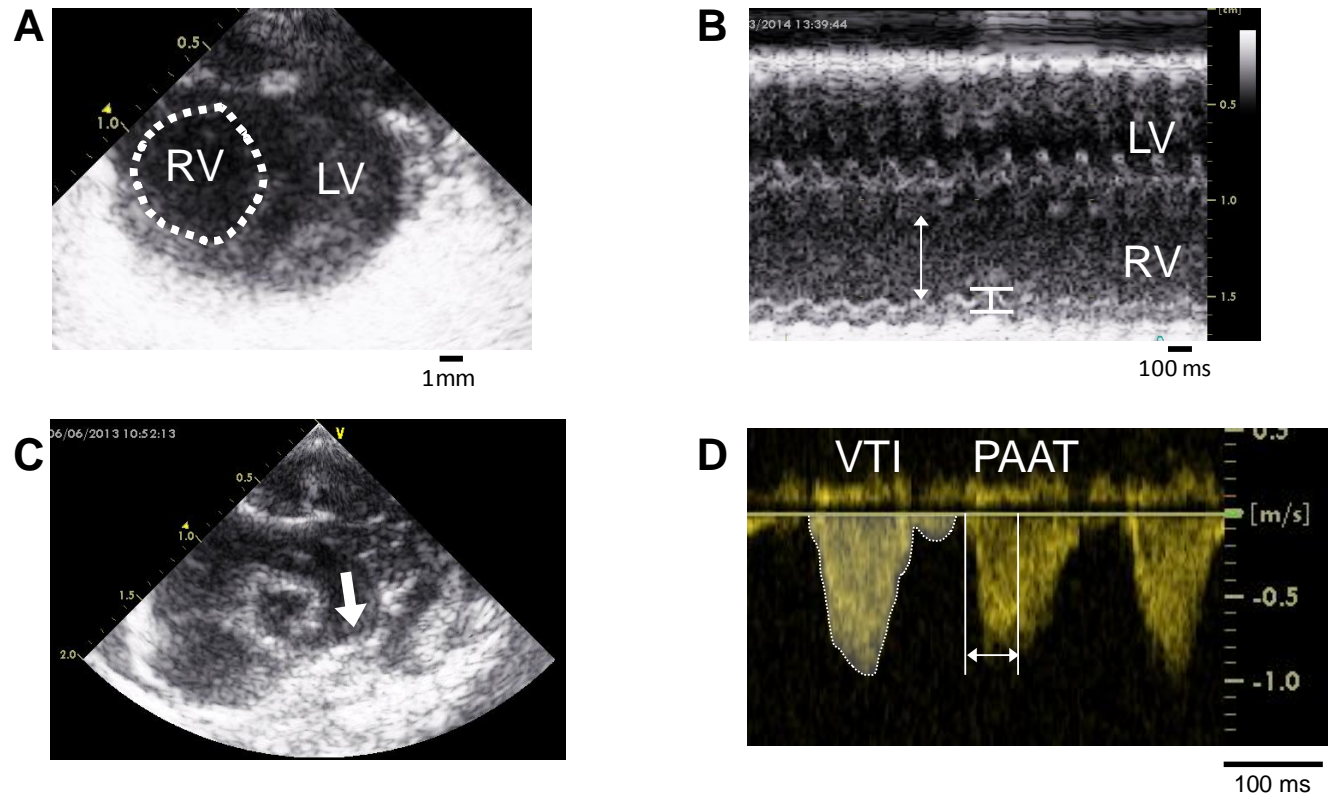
Echocardiography measurement modes
